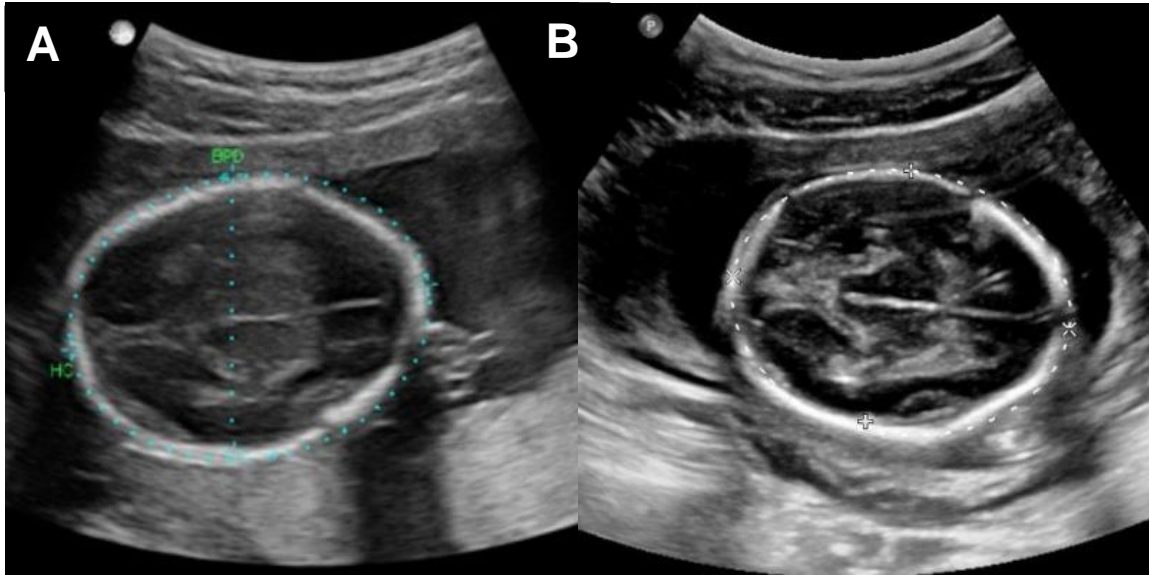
Representative ultrasound images demonstrating equivalence of measurement of biparietal diameter and head circumference using the (A) telerobotic ultrasound system and (B) conventional ultrasound system.
